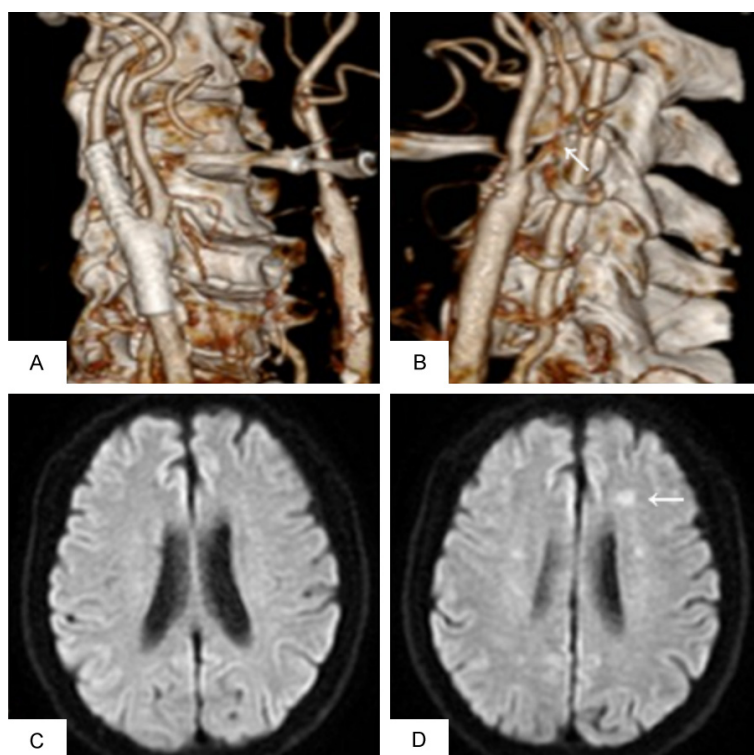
A. Carotid CTA after right internal carotid artery stent implantation; B. Carotid CTA showed spontaneous recanalization of the left internal carotid artery, and severe stenosis of local lumen; C. Before carotid artery stenting, the head MRI diffusion weighted image (DWI) of the same patient showed no infarction at the same level; D. The white arrow shows multiple new infarcts in the left frontal lobe in the head MRI-DWI.
